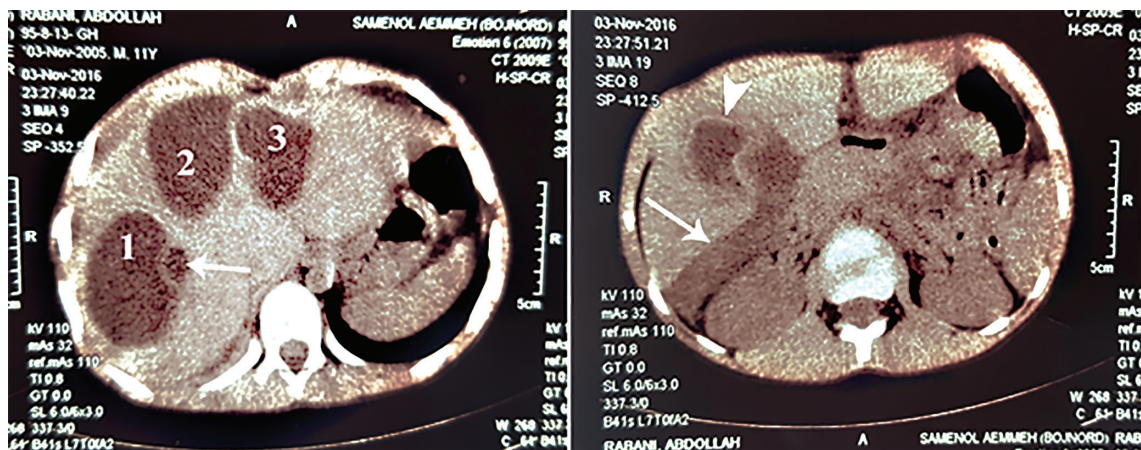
A computed tomography scan of the abdomen showing three liver hydatid cysts (1, 2, and 3) with a small daughter cyst (arrow) (left) and a ruptured liver cyst (arrow head) causing pleural effusion (arrow) (right) in the abdominal space of the patient before surgery.
